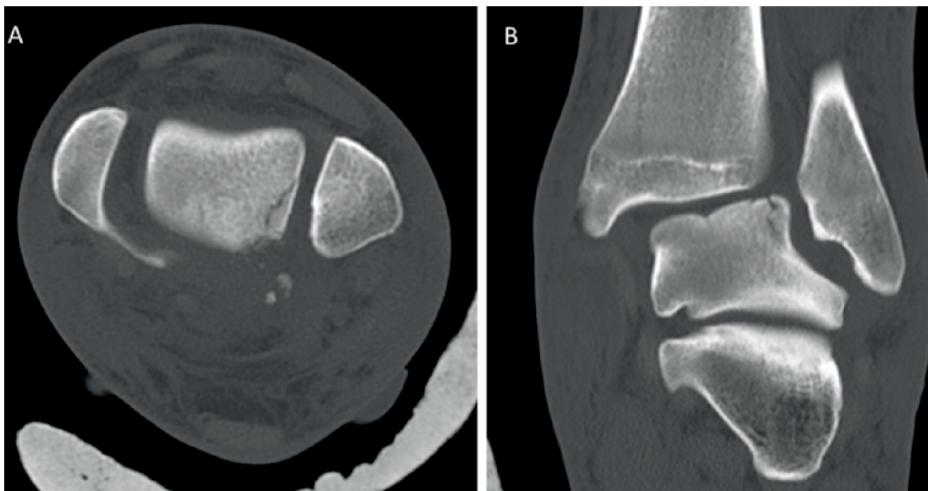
Preoperative (A) axial and (B) coronal CT images from a patient with a pronation-external rotation injury type IV with a large osteochondral lesion type III.
